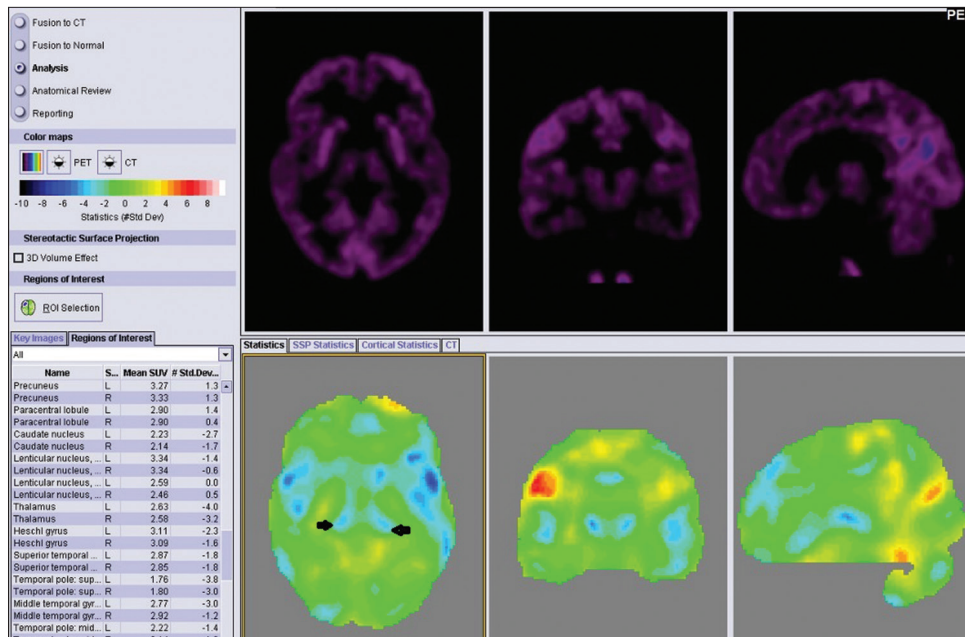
Scenium software images of FDG brain showing hypometabolism in both thalami (black arrows) (3–4 standard deviation less than normal population). Also mild caudate and temporal hypometabolism noted (2–3 standard deviation less than normal). (Blue color indicates hypometabolism). FDG: Fluorodeoxyglucose
